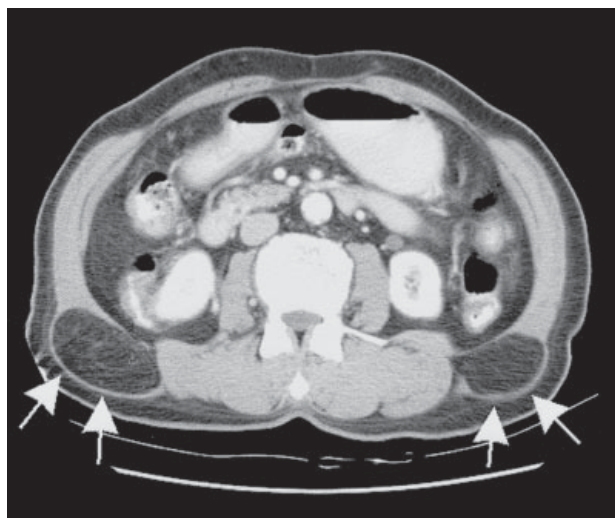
Computed tomography scan at the lower aspect of the flank masses showed bilateral, well-circumscribed, fat-containing flank masses (arrows), suggestive of bilateral lipomas.
